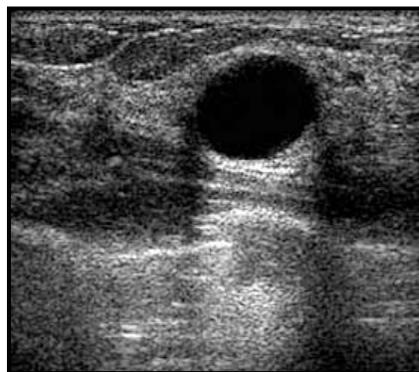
Ultrasound image of a cyst in the breast (non-cancerous), with a FOV of approximately 4cm (Mayo Clinic, 2008).
